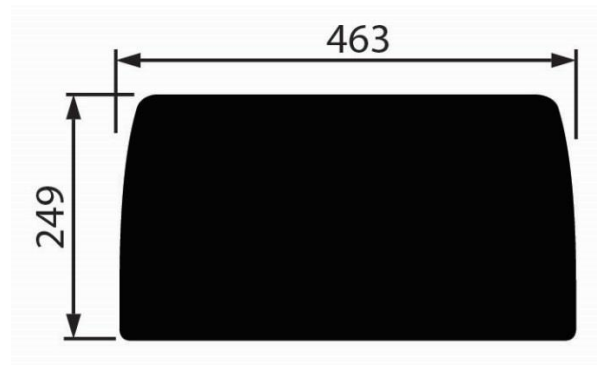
Adept Medical X-Ray Shield Dimensions
